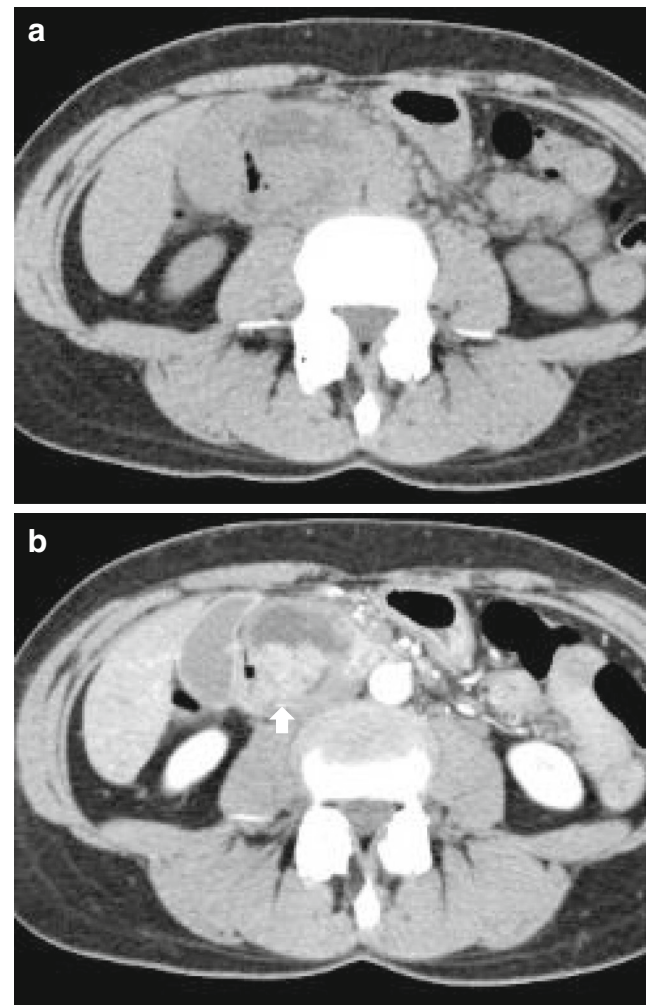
a Contrast-enhanced computed tomography (CT) image showing cystic lesion in the head of the pancreas. b Contrast-enhanced CT image showing tumor-containing mural nodule components (white arrowhead)
